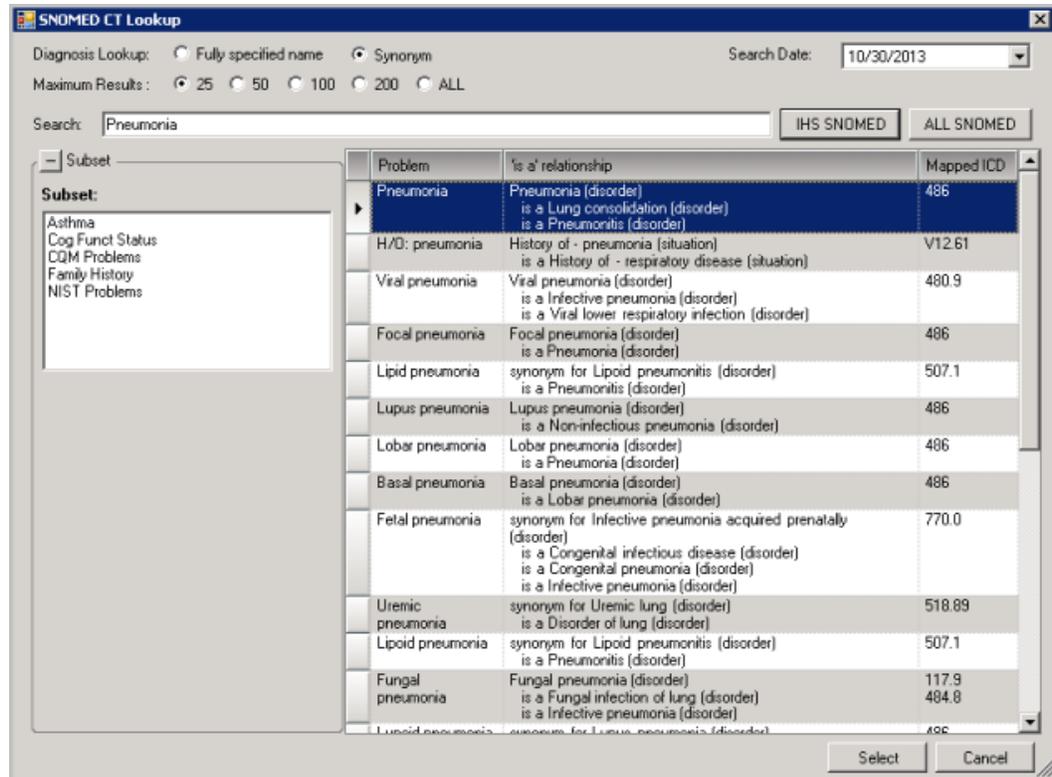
SNOMED CT dialog
